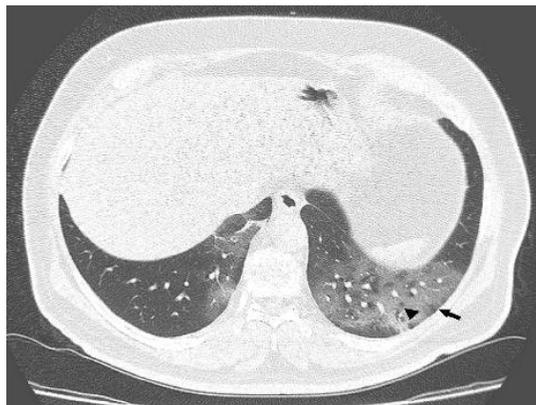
A case of COVID-19 pneumonia confirmed by RT-PCR. 72-year-old man, day 4 after symptom onset, with severe severity criteria. Axial chest CT shows bilateral diffuse subpleural ground-glass opacities (arrows) and crazy paving (arrowheads). Patient died 2 days later.
